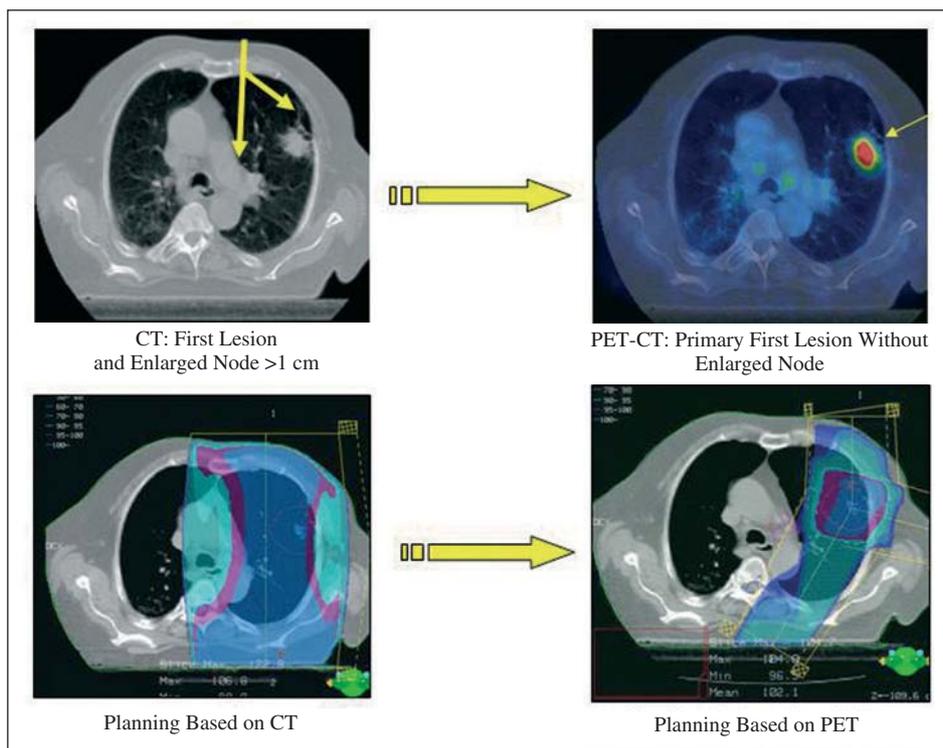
Radiation therapy planning based on positron emission tomography (PET). Reduction in target tumor volume. CT indicates computed tomography.
